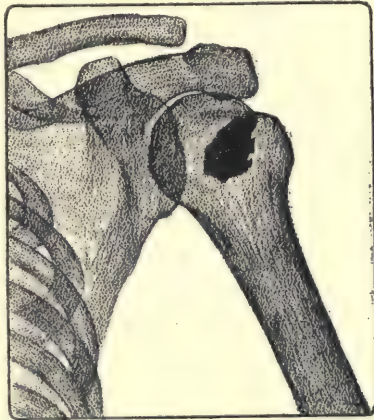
Radiograph of the right shoulder seen from the back. A very dense irregular shadow which closely resembles the shadow of a metal fragment is seen on the shadow of the humeral head. It is an iodoform dressing in the head of the humerus.
